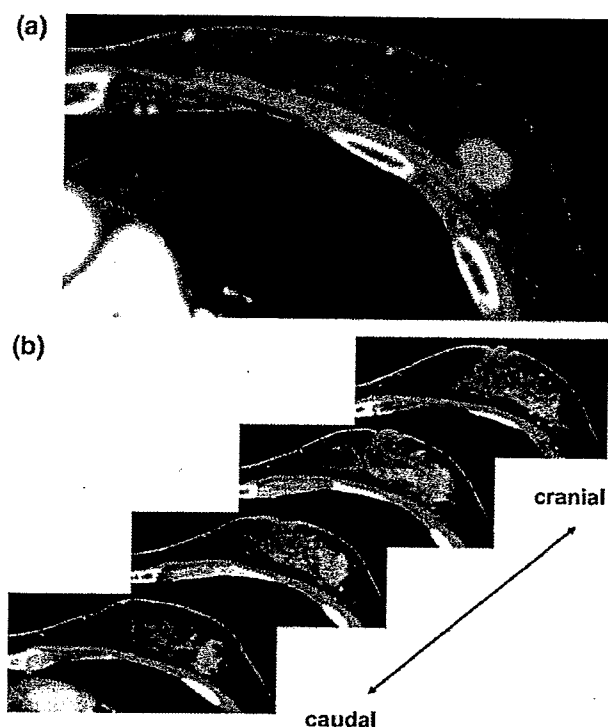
Classification of invasive lobular carcinoma by CT imaging. a Localized tumor type, b non-localized tumor type
